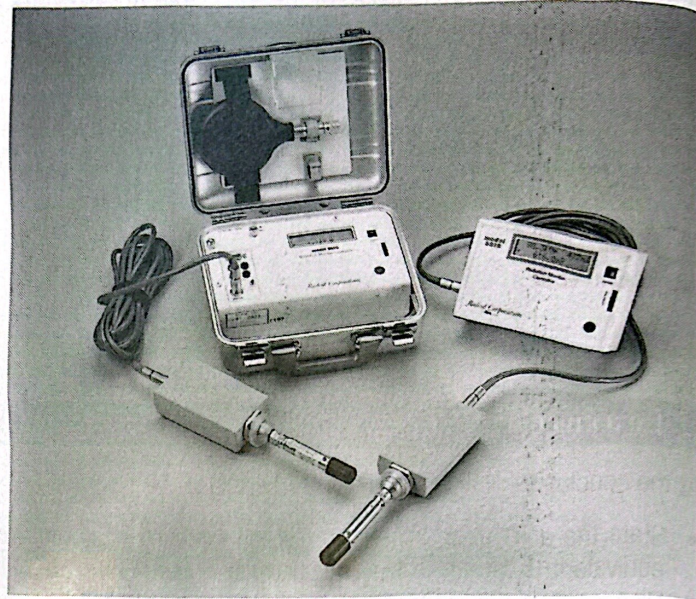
An ionization chamber dosimeter used for accurate measurement of diagnostic x-rays.
